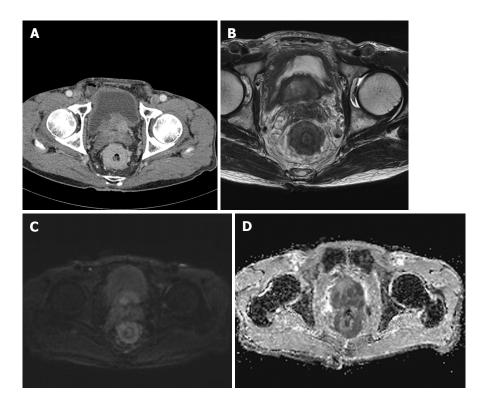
Contrast-enhanced computed tomography and pelvic magnetic resonance imaging of secondary rectal linitis plastica from prostate cancer.
